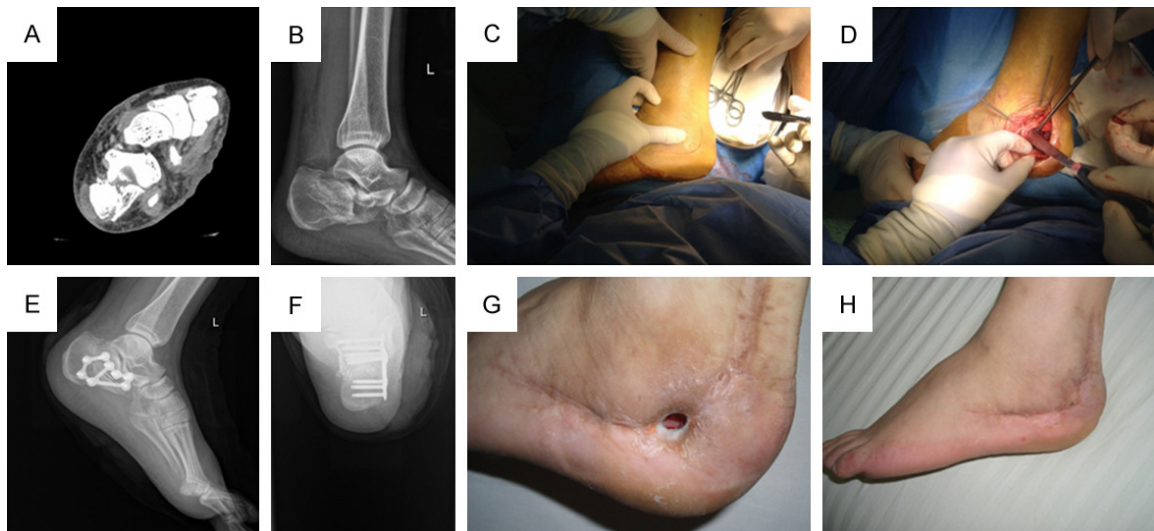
Open reduction via an extended L-shaped lateral approach. Preoperative lateral X-ray showed the intra-articular calcaneal fractures, with decreased calcaneal height, Gissane angle, and Böhler angle (A, B); The L-shaped incision was made (C) and the paries lateralis was opened to expose the fracture ends and poke (D); Postoperative X-ray showed that the calcaneal height, Böhler angle, Gissane angle, and calcaneal width were recovered (E, F); Incision healed was delayed, but resolved after one month by dressing change (G, H).
